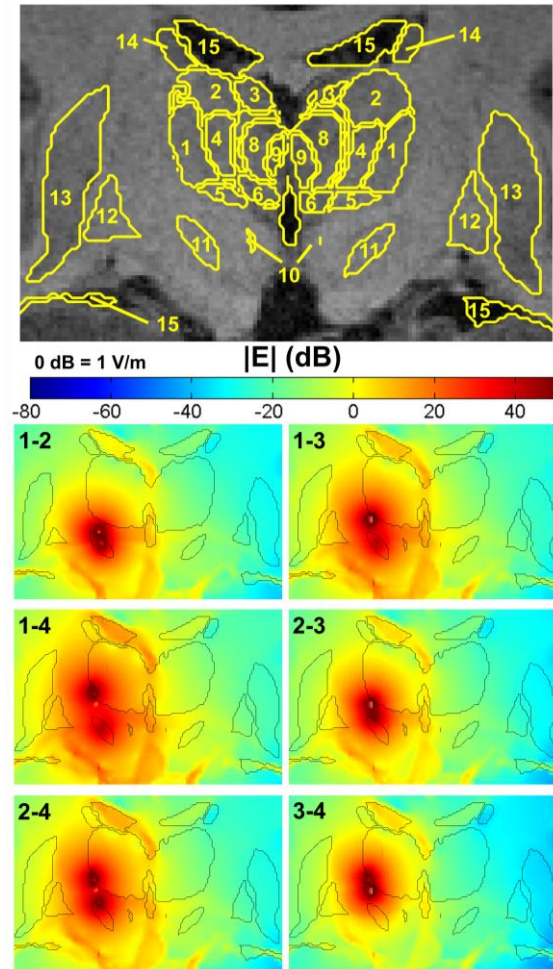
(*Top*) coronal view of the thalamic nuclei on the T1-weighted MRI. Legend of the segmented nuclei: 1 VLa; 2 VLpd; 3 AV; 4 VLpv; 5 VM; 6 CeM; 7 CL; 8 MDpc; 9 MDmc; 10 mtt; 11 STN; 12 pallidum; 13 putamen; 14 caudate; 15 ventricles. (*Bottom*) Magnitude of electric field in the nuclei for the 6 bipolar configurations (1-2, 1-3, 1-4, 2-3, 2-4, 3-4).
